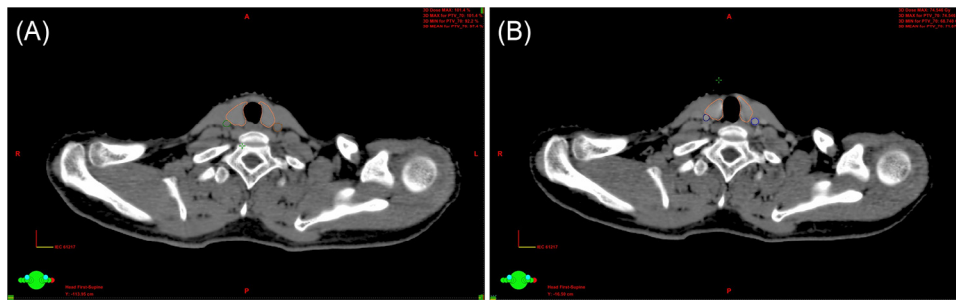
Computed tomography images of a patient showing the locations of right common carotid artery, left common carotid artery, and the thyroid. (A) Without intravenous contrast injection (right common carotid artery in green, left common carotid artery in brown, and thyroid in orange). (B) With intravenous contrast injection (right common carotid artery in deep blue, left common carotid artery in blue, and thyroid in orange). (Color version of figure is available online.)
